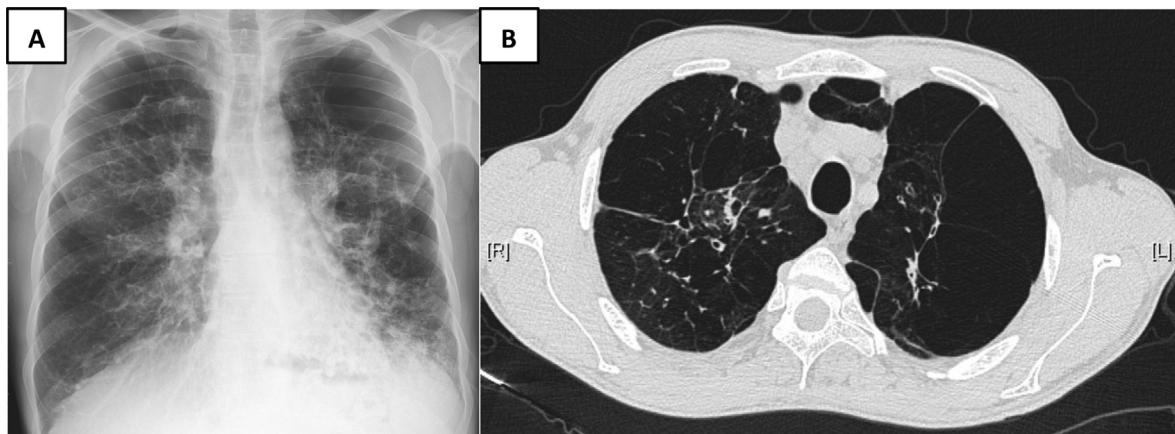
Demonstrates imaging from a CF patient with a suspected left apical pneumothorax on chest radiograph (A). On CT chest this was shown to be a large bulla (B).
